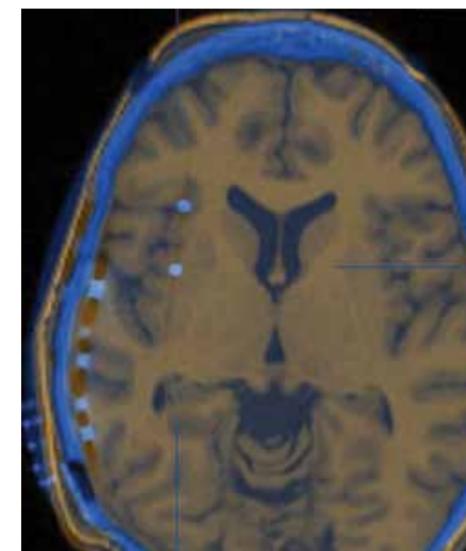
Example of fused postoperative computed tomography and preoperative magnetic resonance imaging demonstrates depth electrode placed in the insula, a sensitive structure because the Sylvian fissure with the middle cerebral artery branches is merely millimeters away. The subdural grid is also visible.
